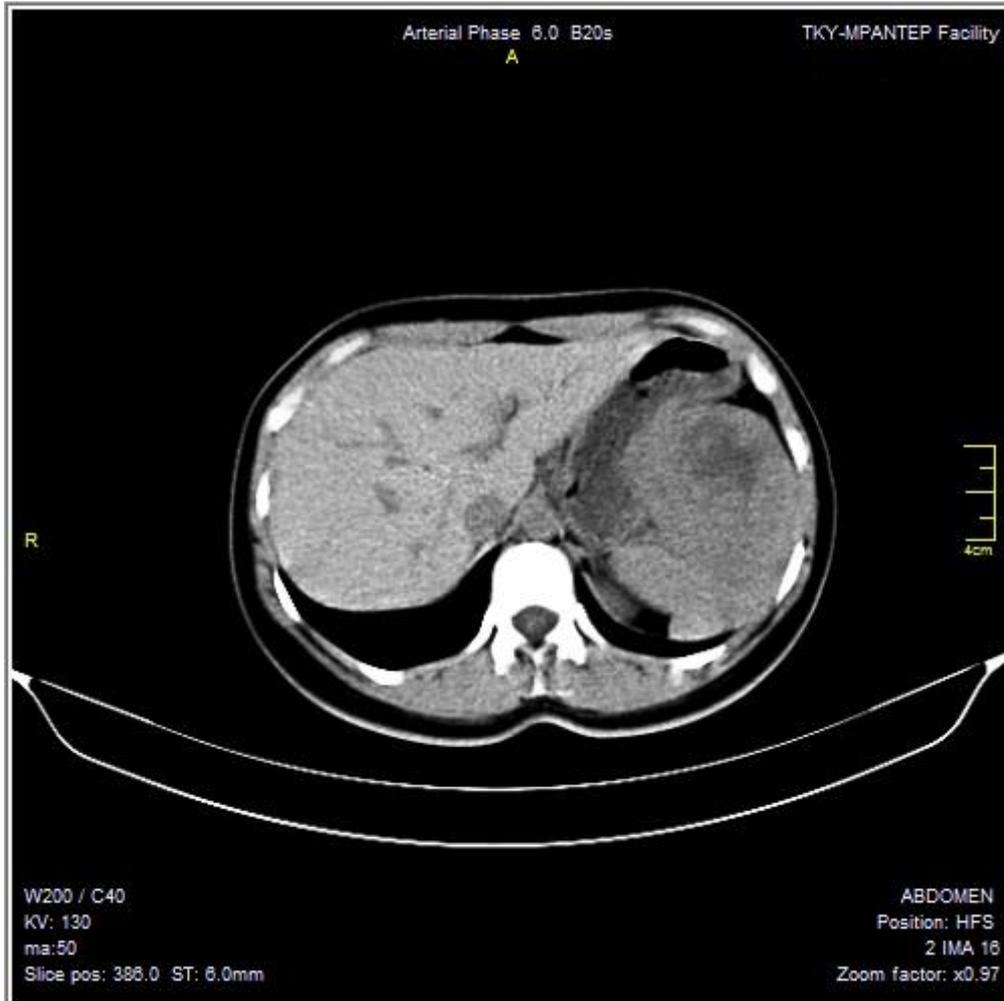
Abdominal CT shows a lobulated-contoured splenic mass including central cystic necrotic fields originating from upper half portion of the spleen extending to subdiaphragmatic and gastrosplenic areas.
